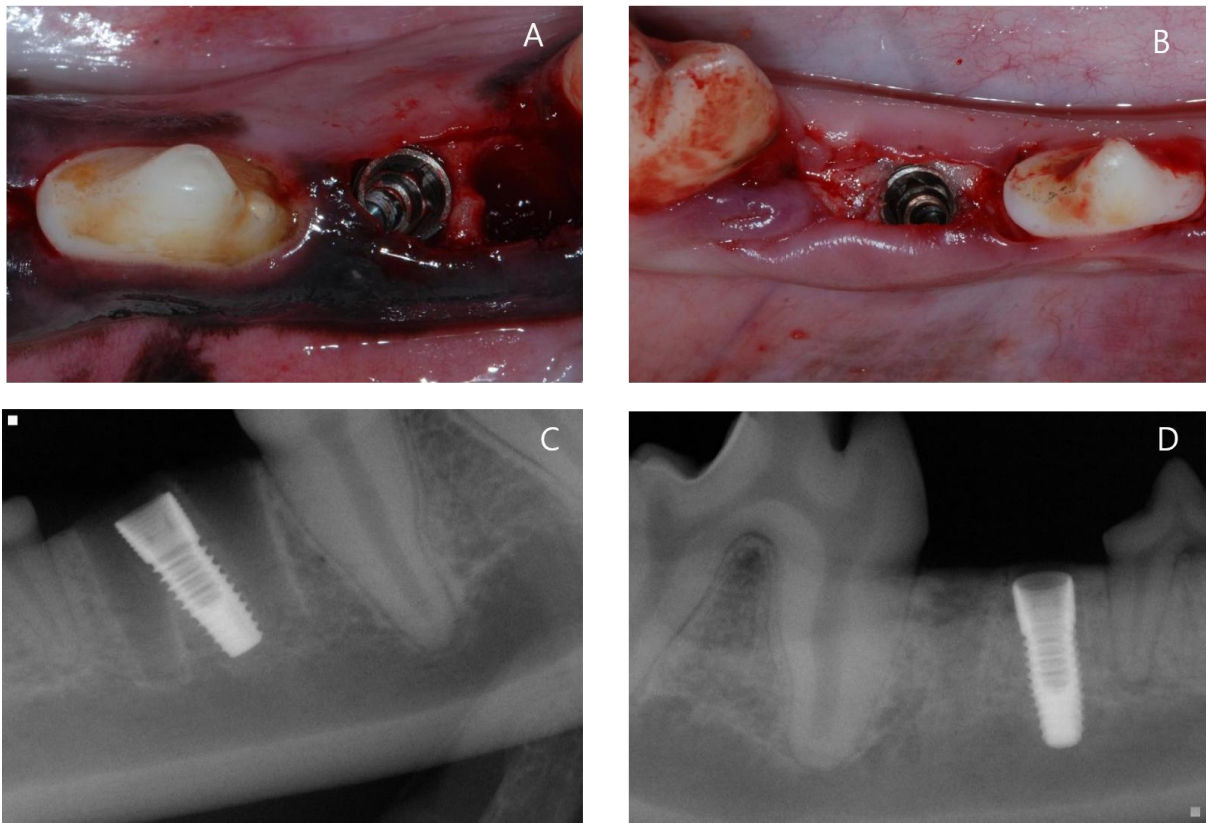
Clinical photos of immediate implant placement (A) and implant placement 2 months after extraction (B). Corresponding periapical radiographs of immediate implant placement (C) and implant placement 2 months after extraction (D).
